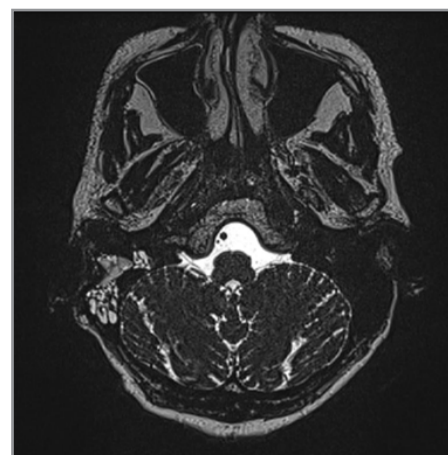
(MRI scan: chronic inflammatory changes of paranasal sinuses)
